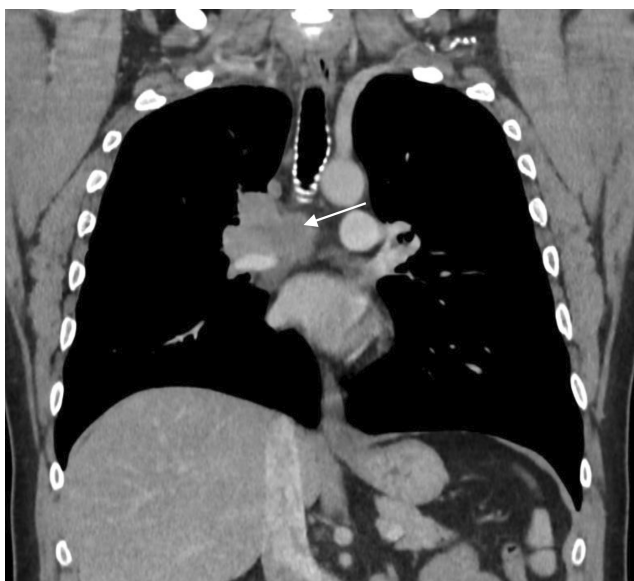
Coronal reformatted image of a contrast CT study of the chest shows a solid infiltrative right hilar soft tissue density mass invading the mediastinum (arrow).
